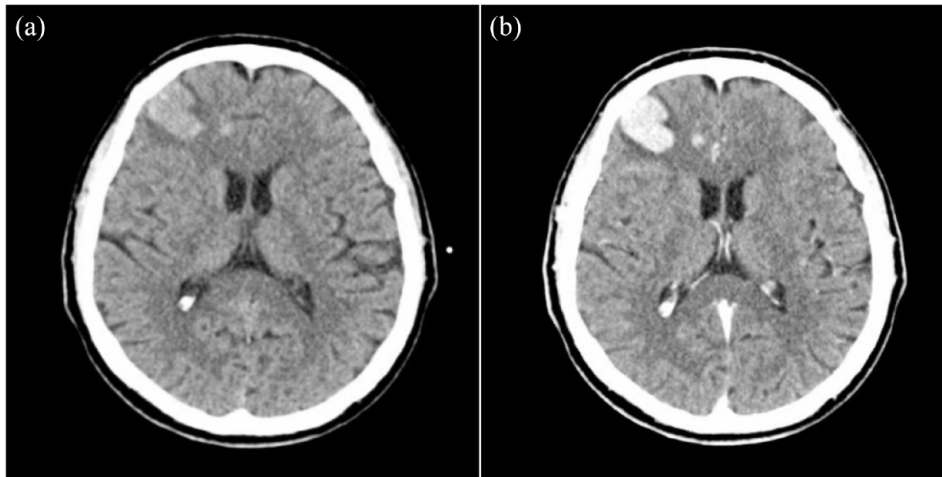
Presentation of hemorrhagic brain metastases in a 62-year-old patient with melanoma. (a) Non-contrast-enhanced computed tomography shows an area of hemorrhage in the subcortical region of the right frontal lobe with perihematomal edema and suspicion of small hemorrhage medially. (b) Contrast-enhanced computed tomography reveals more areas suspicious of malignancy and abnormal vascularity.
